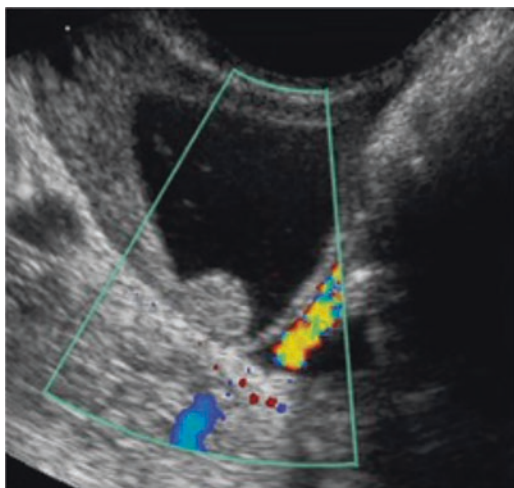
Nodule (non-hyperechoic) without blood flow. Surgical evaluation or MRI should be considered
